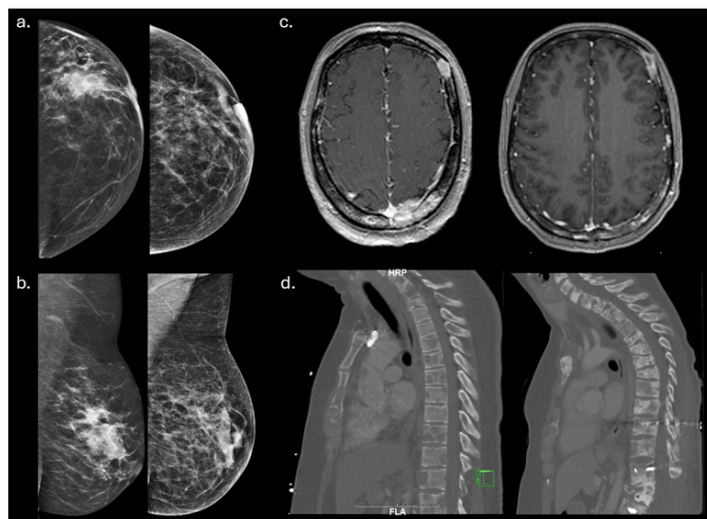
Patient 1: (a) Craniocaudal (CC) Mammogram pre-treatment (left) and post-treatment (right) with cDC1 vaccine demonstrating interval decrease in mass density. (b) Mediolateral Oblique (MLO) Mammogram pre-treatment (left) and post-treatment (right) with cDC1 vaccine demonstrating interval decrease in mass density. (c) Brain MRI pre-treatment (left) and post-treatment (right) with cDC1 vaccine. Post-treatment MRI demonstrates significantly reduced enhancement in calvarium and improved dural extension. (d) CT Thorax, Abdomen, Pelvis pre-treatment (left) and post-treatment (right) with cDC1 vaccine demonstrates diffuse pre-treatment lytic metastases converting to post-treatment sclerotic bone metastases.
